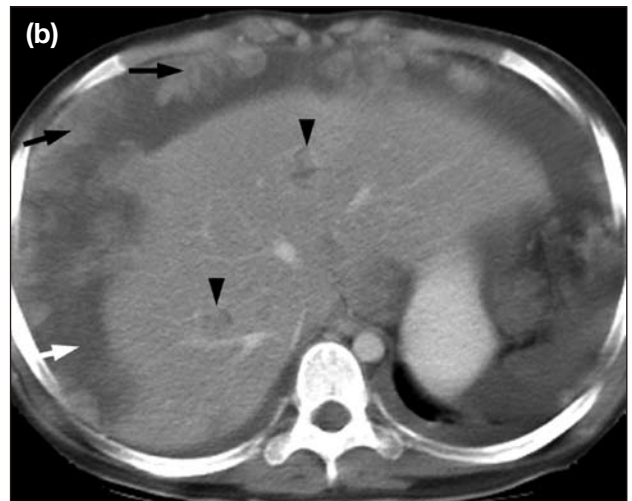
Contrast-enhanced axial computed tomography images of the upper abdomen showing (a) bilateral obstructive hydronephrosis (curved arrows); and (b) ill-defined metastatic lesions in the liver (black arrow heads), multiple metastatic omental soft tissue nodules (black arrows), and ascites (white arrow).
